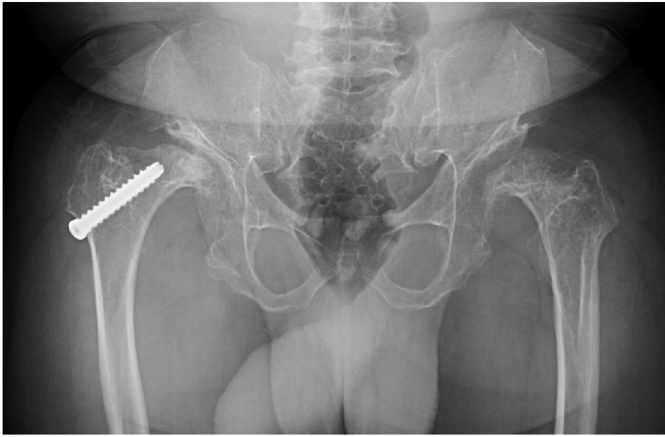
Bilateral hip preoperative radiograph with a demonstration of right femoral screw. Imaging of the pelvis redemonstrates bilateral hip dysplasia and lacy pelvis.
